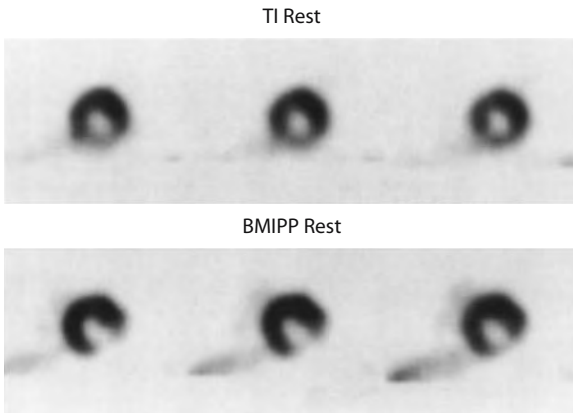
Comparison of regional myocardial blood flow as assessed at rest with ^{201}Tl (TL REST) and fatty acid uptake (BMIPP REST). Note the more severely reduced BMIPP uptake in the inferolateral wall on the short-axis SPECT images in a patient with coronary artery disease. (From TAMAKI et al. 1996)
